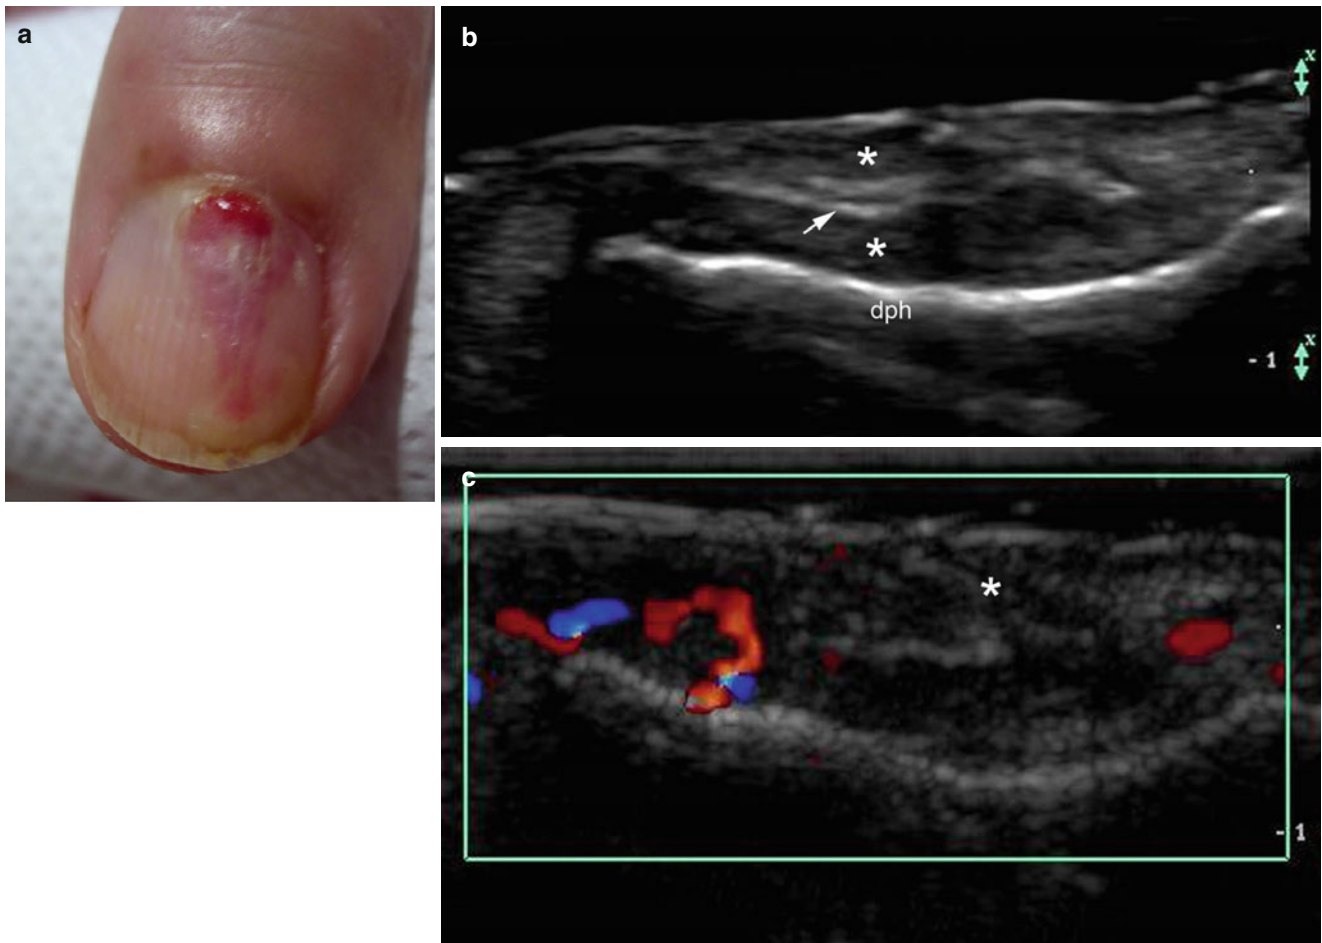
(a–c) Subungual abscess. (a) Clinical image shows discharge of sero-hematic material and erythema in the nail of the left thumb. (b) Grey scale ultrasound image (longitudinal view, left thumb) shows hypoechoic subungual collection (*) that surrounds a nail plate
